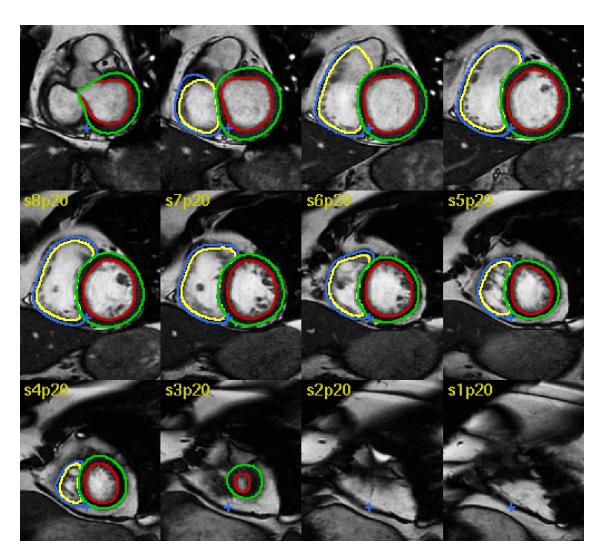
Example of an automatically segmented cardiac MRI with RV dysfunction and RV dilatation. The AI model was particularly accurate at segmenting the RV base, which is the area typically most challenging for manual assessors.
